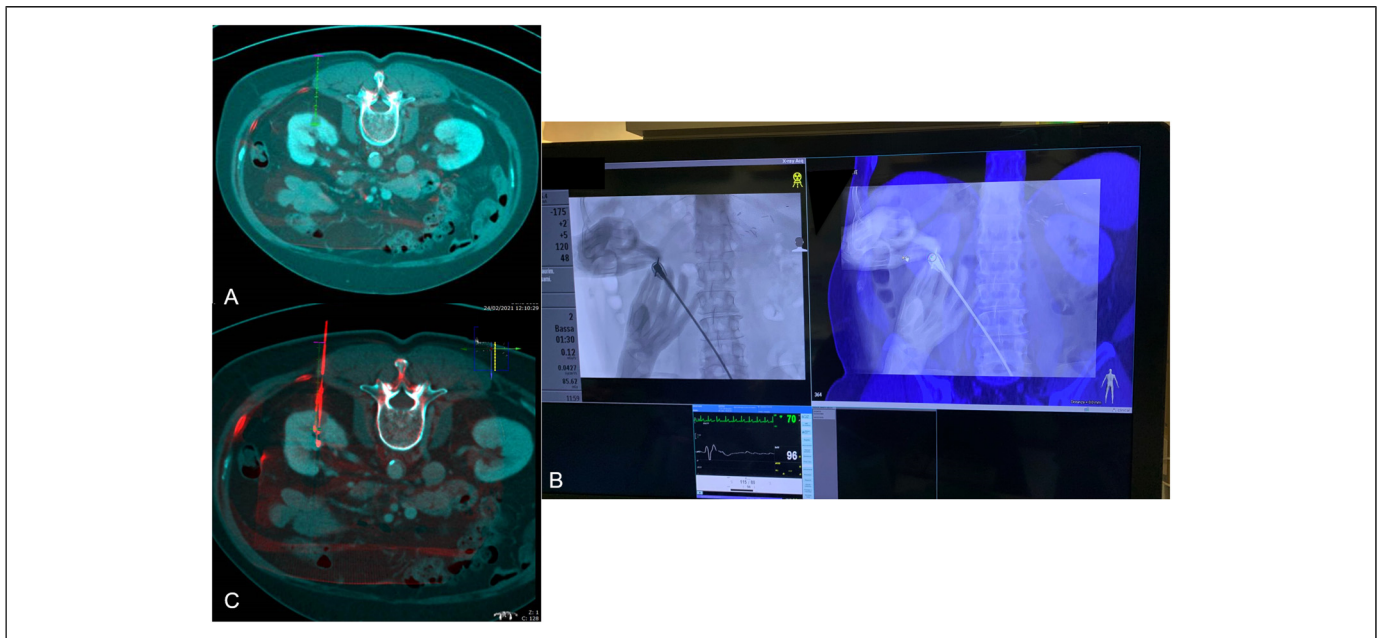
Target point and entry point were drawn using the antenna navigation software (XperGuide) on the merged image (A); under fluoroscopic guidance, the antenna was positioned following the path drawn (B); further CBCT scan was obtained to check the position of the antenna (C).
